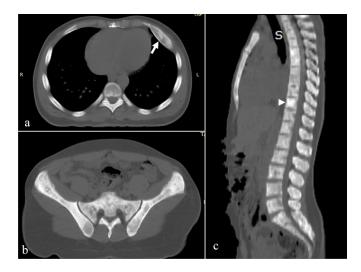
(a) Axial unenhanced CT, bone window of the chest showing focal rib expansion (white arrow). (b) and (c) show osteoblastic changes at the sacrum, iliac bones, sternum and vertebrae. Ivory vertebra depicted by arrowhead.
